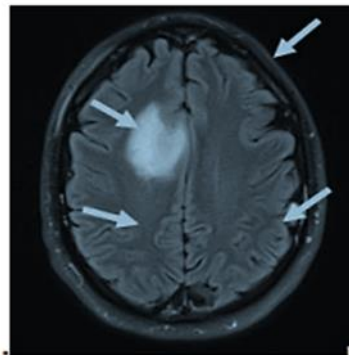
MRI of brain tumor
